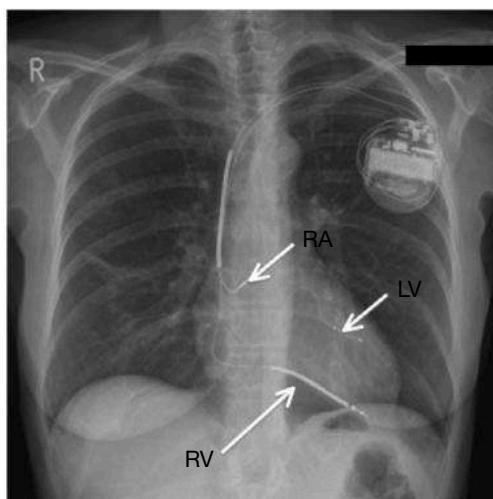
Chest X-ray of a biventricular pacemaker and defibrillator (cardiac resynchronisation therapy). The right ventricular lead (RV) is in position in the ventricular apex and is used for both pacing and defibrillation. The left ventricular lead (LV) is placed via the coronary sinus, and the right atrial lead (RA) is placed in the right atrial appendage; both are used for pacing only.
